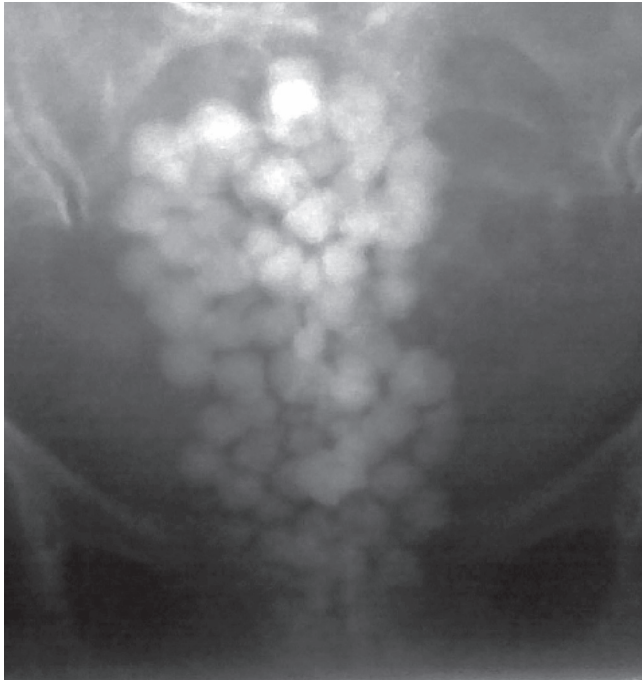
KUB X-rays showing bladder calculi
